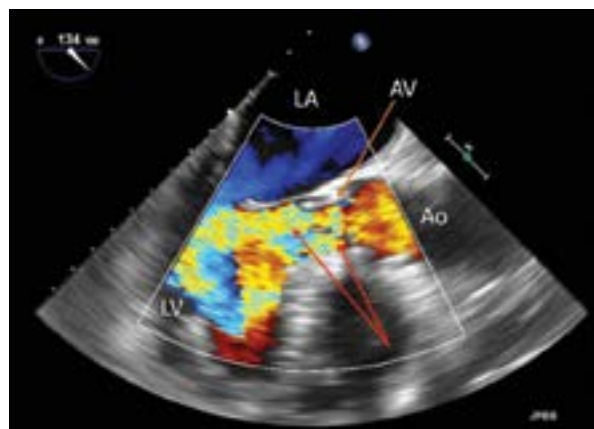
Severe aortic regurgitation caused by endocarditis: two jets of regurgitation (red arrows). Transoesophageal echocardiography (TEE), colour Doppler; Ao – aorta; AV – aortic valve; LA – left atrium; LV – left ventricle
